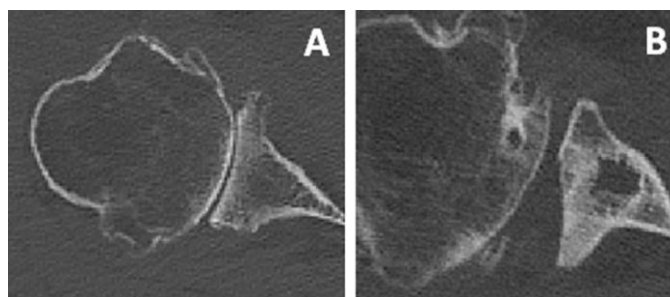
Representative axial CT images of glenoid erosion associated with osteoarthritis.
